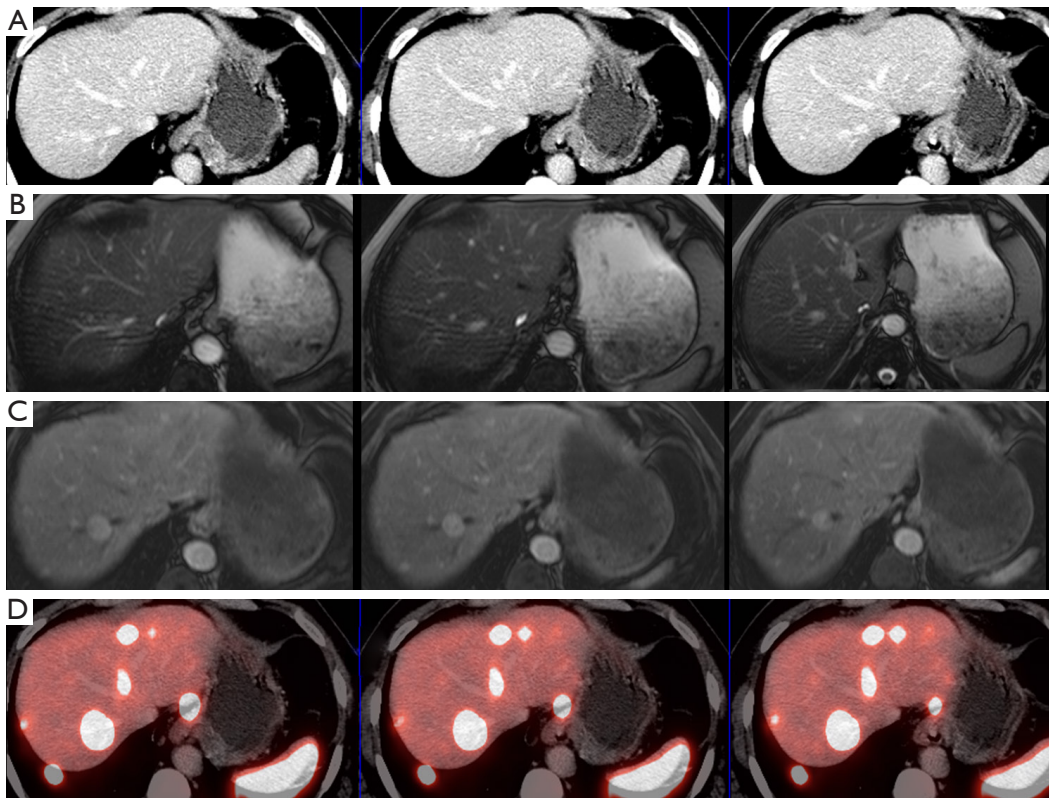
This series of images (transverse view) of CECT (row A), MRI (rows B and C) and Ga-68 SSTR PET/CT (row D) shows a discordance between morphological and molecular imaging. Whereas, receptor PET/CT exhibits multiple liver metastases, only few of which are demonstrated on MRI with contrast (in T1 sequence, row C), CECT is completely negative.
